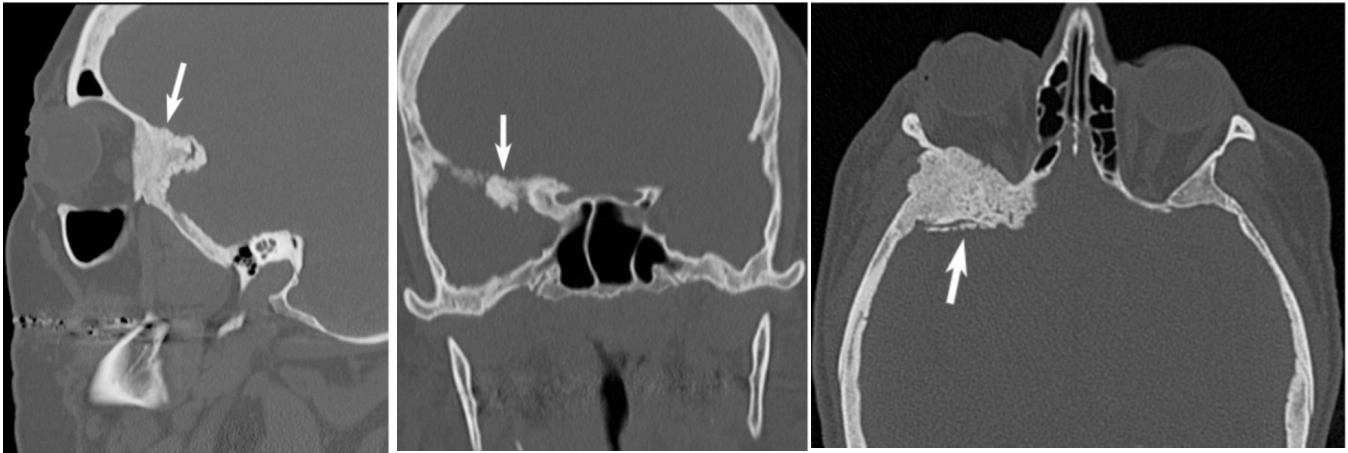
50-year-old female with intraosseous meningioma. Sagittal (left), coronal (middle), and axial (right) CT images of the orbit in bone algorithm demonstrate an infiltrative osseous mass (arrows) involving the right orbital wall, orbital apex, and adjacent sphenoid wing with extension to involve anterior clinoid process on the right. (Note: normal appearance of left clinoid process). Linear dural reaction also noted particularly on the right axial image (arrow).
